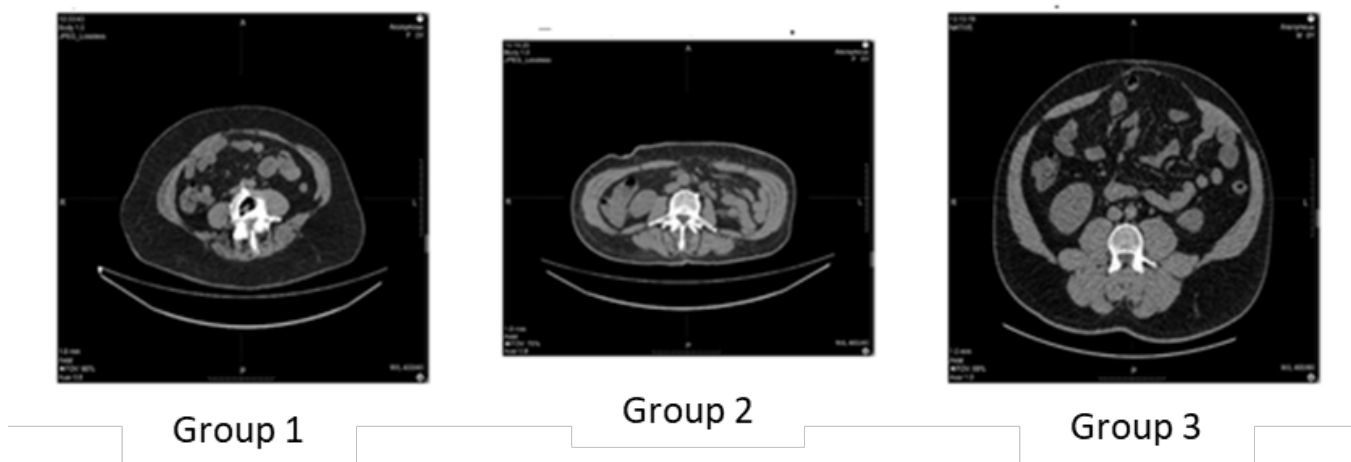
Example of a CT series in the axial projection for segmentation
